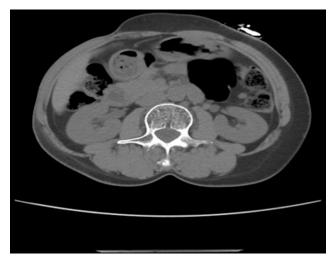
CT image of localized lipoatrophy in the right abdomen.
